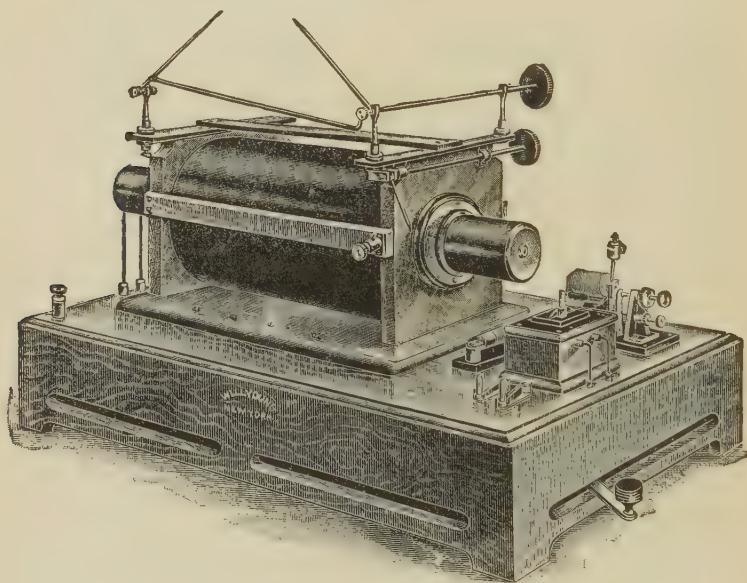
Roentgen Ray Coil.
